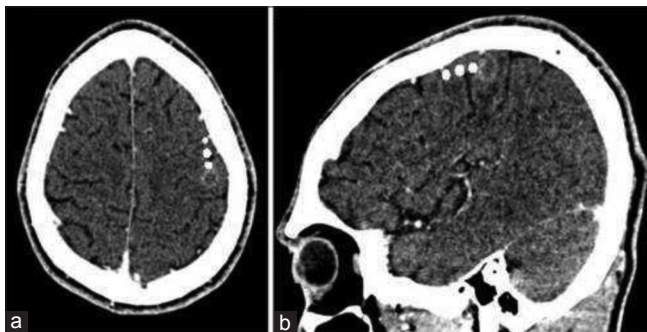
Navigated transcranial magnetic stimulation motor mapping final result. Any motor evoked potential amplitude >50 microvolts (peak-to-peak) were considered positive and exported to digital imaging and communications in medicine format as a white spot. (a) Axial head computed tomography showing the white spots near from lesion area. (b) Sagittal head computed tomography showing the relationship of motor sites and lesion. Again, we can observe close proximity.
